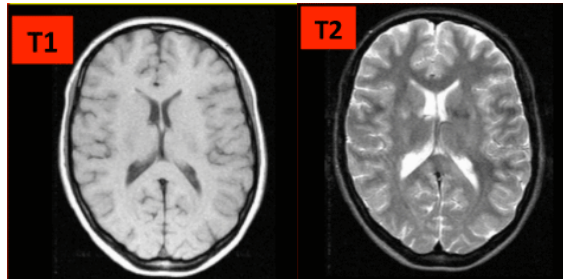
T1-weighted and T2-weighted images. Image reproduced from Elster (2018)
